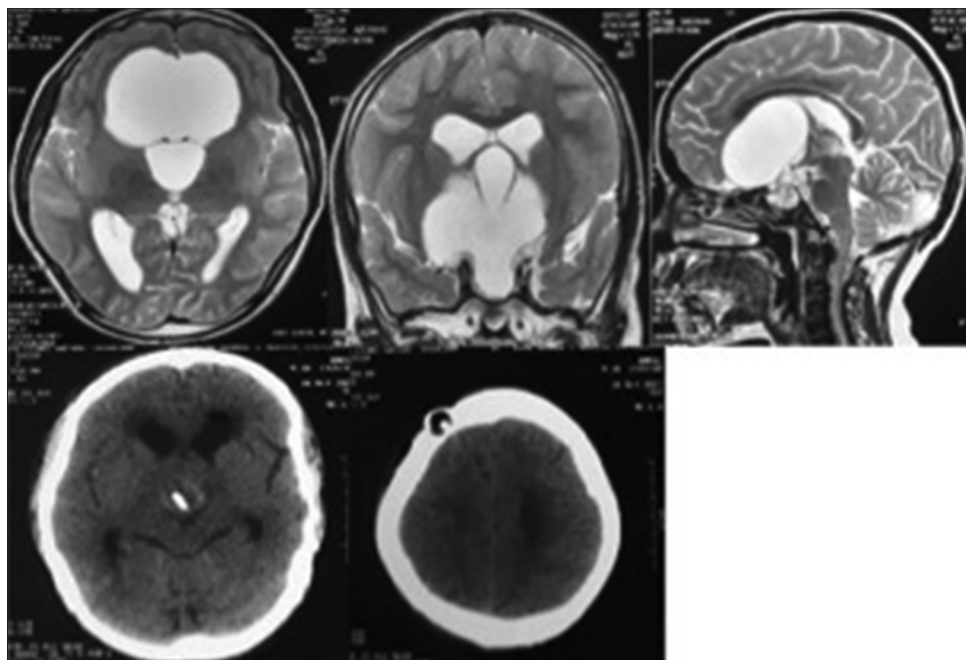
Top row images1-3 – Magnetic resonance imaging T2 images axial, coronal, and sagittal section shows hyperintense cystic craniopharyngioma extending into the third ventricle with ventriculomegaly. Bottom row image 1 and 2 – Computed tomography axial sections show catheter tip into the cystic cavity and Ommaya reservoir at the burr hole site
